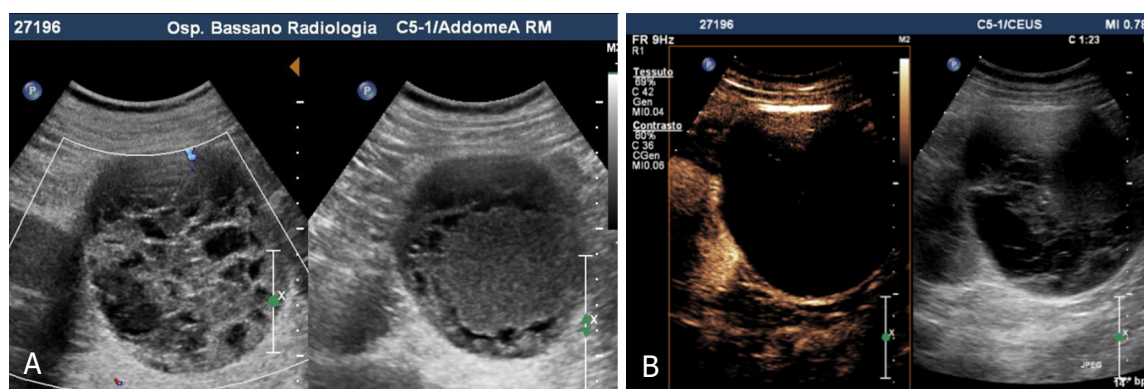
Bosniak 3 cyst. A: Greyscale sonography shows voluminous mass with mixed echo structure (anechoic and hyperechoic components); B: Contrast enhanced sonography reveals cystic lesion characterized by irregular, thickened and vascularized walls
